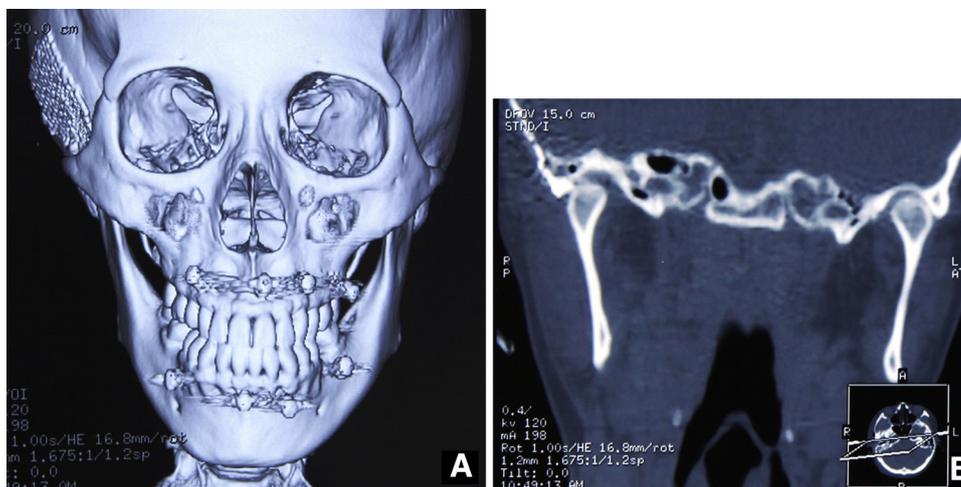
Postoperative CT scans of case 2 at 1 year. (A) Three-dimensional reconstruction CT scan. (B) Coronal CT scan: the condyle is repositioned into the glenoid fossa.
